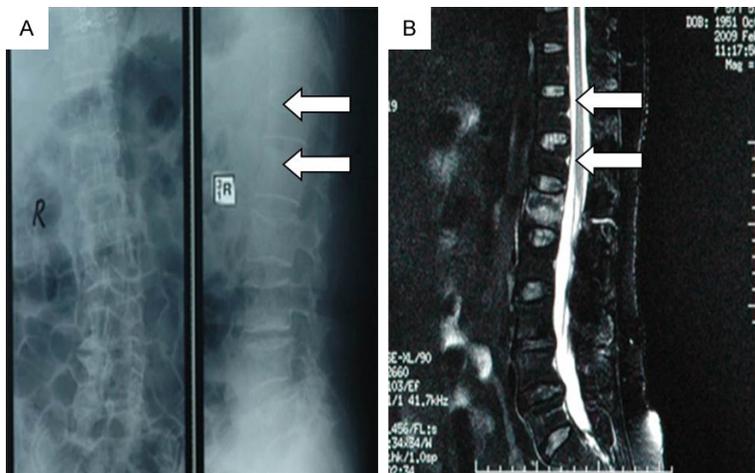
Imaging observation of fracture time. A. X-rays shows wedge-shaped in chest 12 and no vertebral fractures in waist 1. B. MRI $T_2WI + FS$ shows old fracture in chest 12, fresh fracture in waist 1, but no deformation of waist 1 in the vertebral body. Kp surgery on the waist 1 patient, the patient's symptoms eased.
